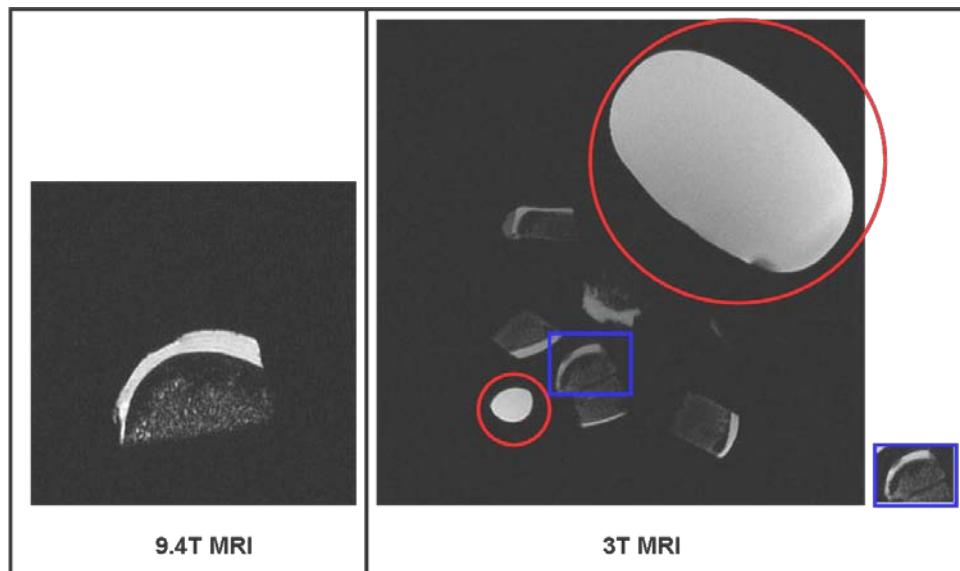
Representative image slices of quantitative morphology MRI of cartilage at 9.4T (left image) and 3.0T (right image). The objects highlighted in red circles were bags of 0.9% (w/v) sodium chloride solution. The 9.4T MR image had obvious superior spatial resolution (8.5 pixels per mm) and contrast to the 3.0T MRI (3.2 pixels per mm), though cartilage defect was visible on both images.
